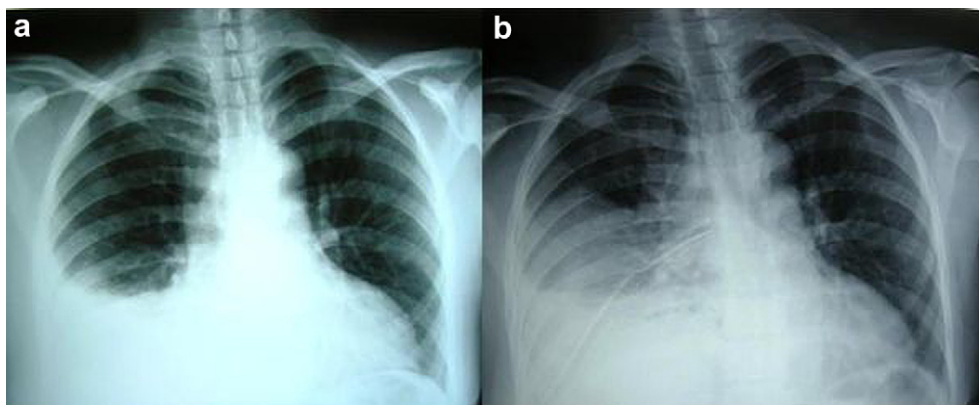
a. Chest radiography of patient at presentation; b. Chest radiography of patient after tube thoracostomy.
